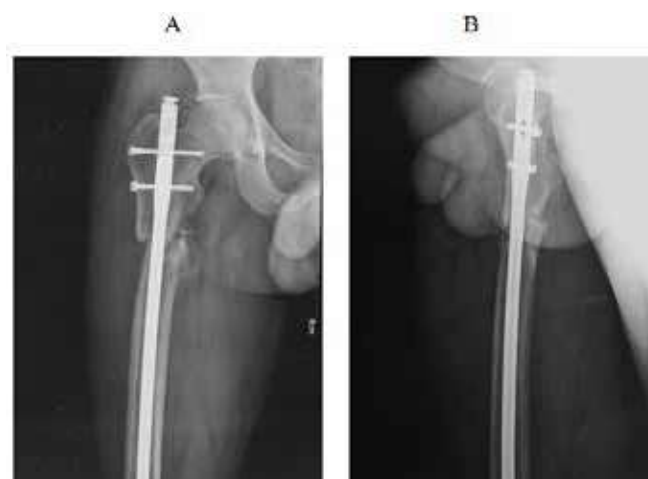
Non-healing X-ray films after intramedullary nail fixation for proximal-segment femoral fracture: positive position (A) and lateral position (B).
